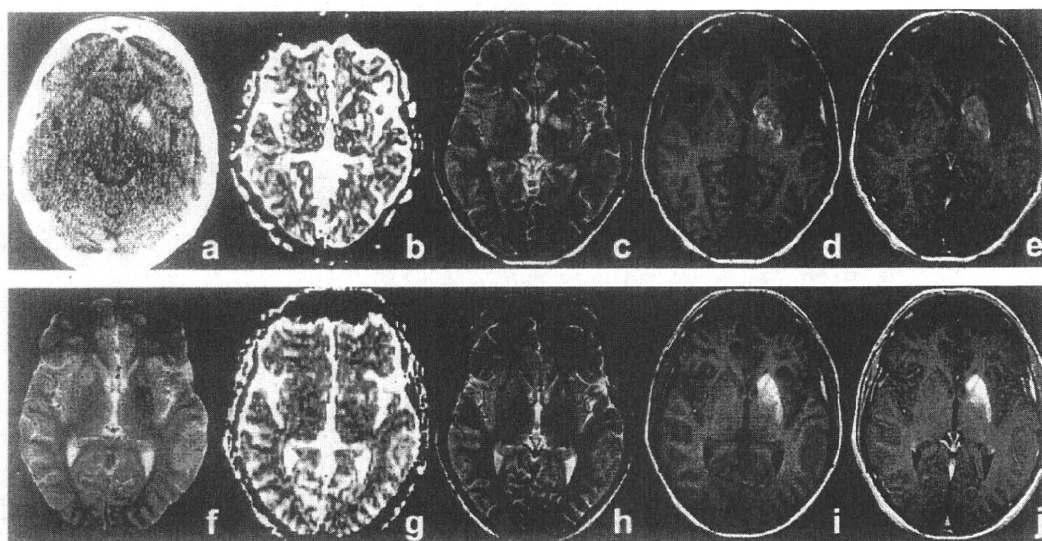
Sequential neuroimaging. (a) Initial computerized tomography: left striatal hyperdensity indicating blood. (b) Initial MRI [parameter map of the apparent diffusion coefficient (ADC)]: slight diffusion restriction in the left basal ganglia. (c) Initial MRI (T2): inhomogeneous signal characteristics of the left basal ganglia with an area of hypointensity consistent with blood particles. (d) Initial MRI (T1): left striatal and pallidal hyperintensities sparing the anterior horn of the internal capsule. (e) Initial MRI (T1 with contrast agent): contrast enhancement can be seen in the left putamen. (f) Follow-up MRI (susceptibility weighted image, T2*): signal drop out in part of the basal ganglia indicating hemosiderin. (g) Follow-up MRI (ADC): no diffusion restriction left in left basal ganglia. (h) Follow-up MRI (T2): diminishing edema of the left basal ganglia compared to (c). (i) Follow-up MRI (T1): homogeneous striatal hyperintensity consistent with early chronic stage of hemorrhage development. (j) Follow-up MRI (T1 with contrast agent): no contrast enhancement left in the basal ganglia lesion.
